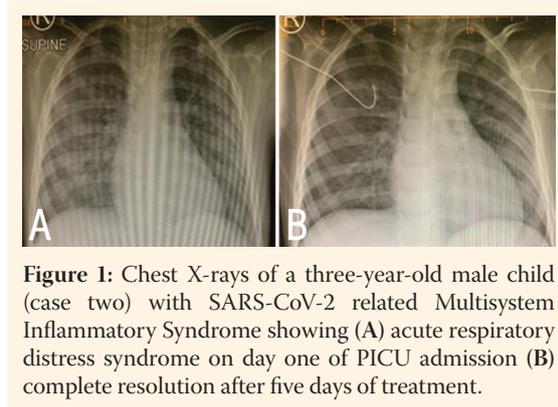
Chest X-rays of a three-year-old male child (case two) with SARS-CoV-2 related Multisystem Inflammatory Syndrome showing (A) acute respiratory distress syndrome on day one of PICU admission (B) complete resolution after five days of treatment.
